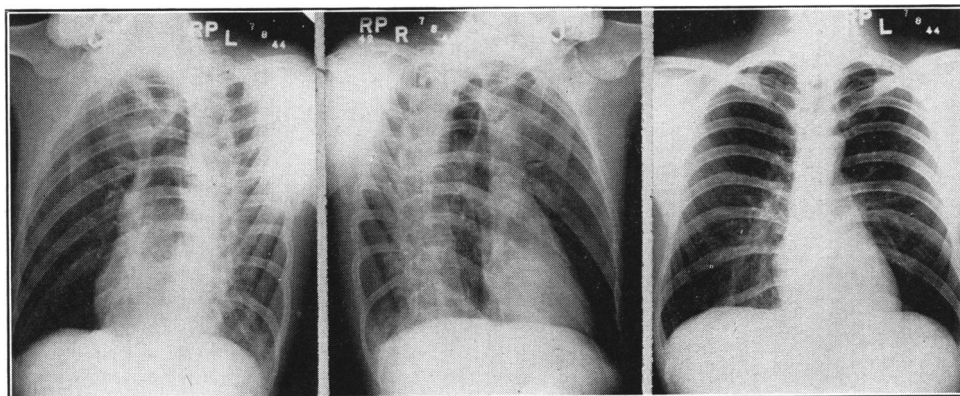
(Case No. 25). A mild case of primary atypical pneumonia. Mild atypical pneumonia began abruptly in this patient 12 days after inoculation. Roentgenogram on the 14th day (July 10th) showed a soft infiltration in the left lower lobe. No abnormal physical signs in the lungs were detected at any time. Neither cold hemagglutinins nor agglutinins for streptococcus #344 were detected in his convalescent sera.
